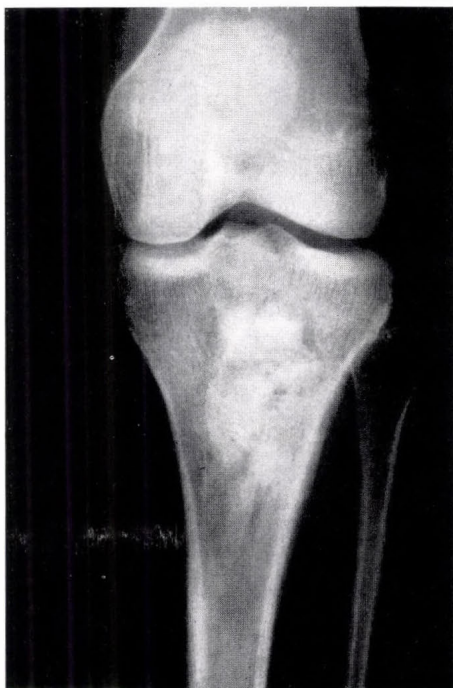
Control X-ray picture after 2 years
